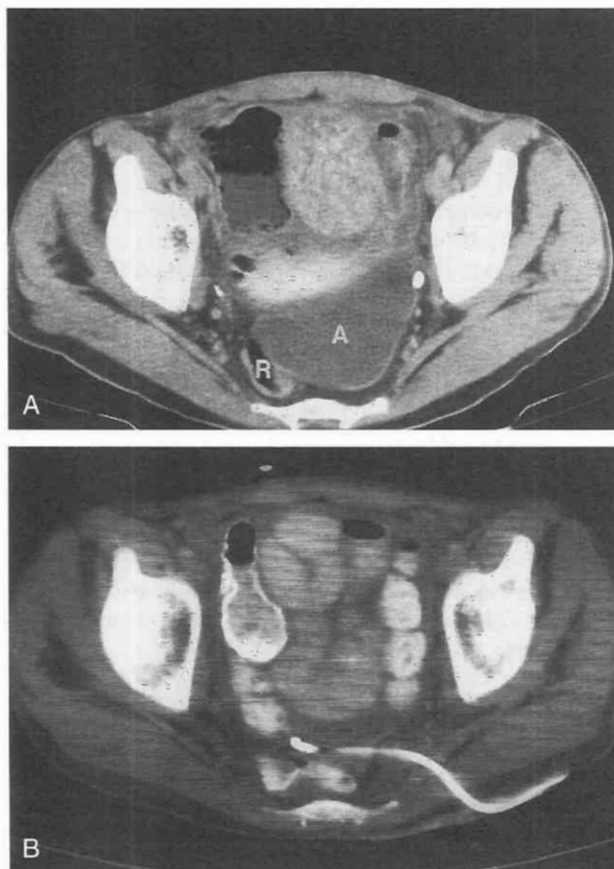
Pelvic abscess. *A*, CT scan shows a pelvic fluid collection (*A*) anterolateral to the rectum (*R*). *B*, CT scan shows successful catheter drainage through the left sciatic notch.
